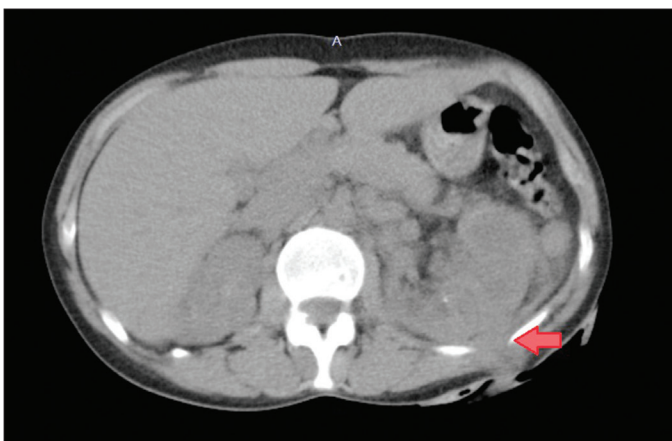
Tract of nephrocutaneous fistula in the left kidney on computed tomography
